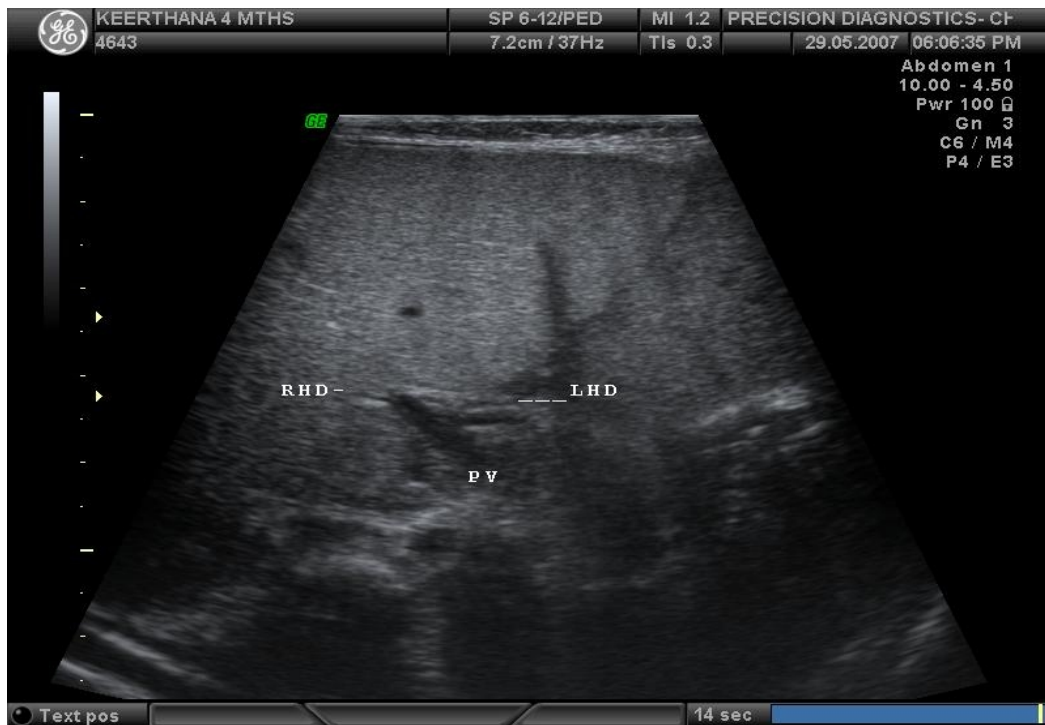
Ultrasonogram showing normal porta hepatis
